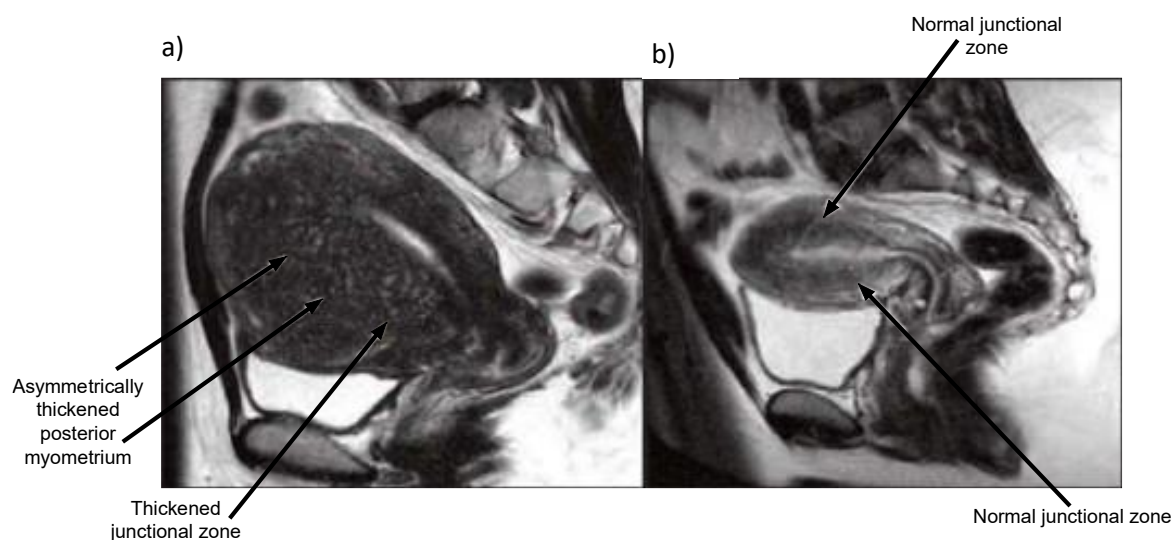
MRI images of the female pelvis: Image (a) demonstrates a thickened Junctional Zone and asymmetric posterior myometrial thickness of an adenomyotic uterus, image (b) shows the appearance of a normal uterus (image from “Progressive Radiology” <https://progressiveradiology.com/news/articles/dr-aimee-maceda-on-adenomyosis>)
